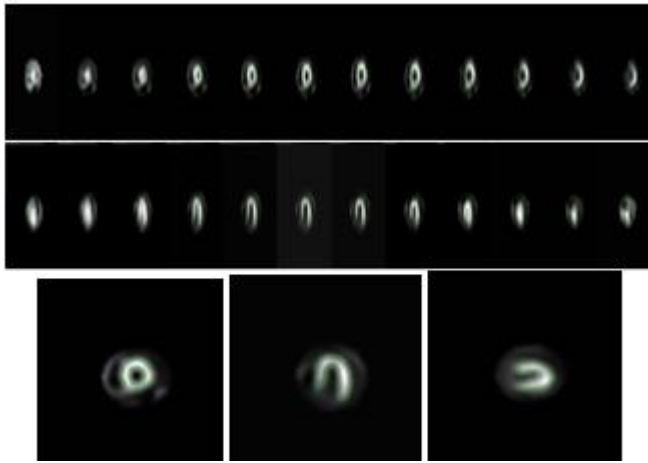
Segmented SPECT image obtained using registration techniques (Normal)
